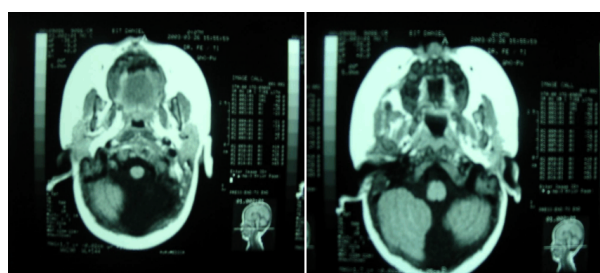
Arachnoid cyst of posterior fossa. Brain MRI: cerebellar interhemispheric arachnoid cyst of approximately 3/3 cm, with asymmetry of cerebellar hemispheres; vermician agenesis, cortico-subcortical atrophy; moderate secondary intern hydrocephaly.
